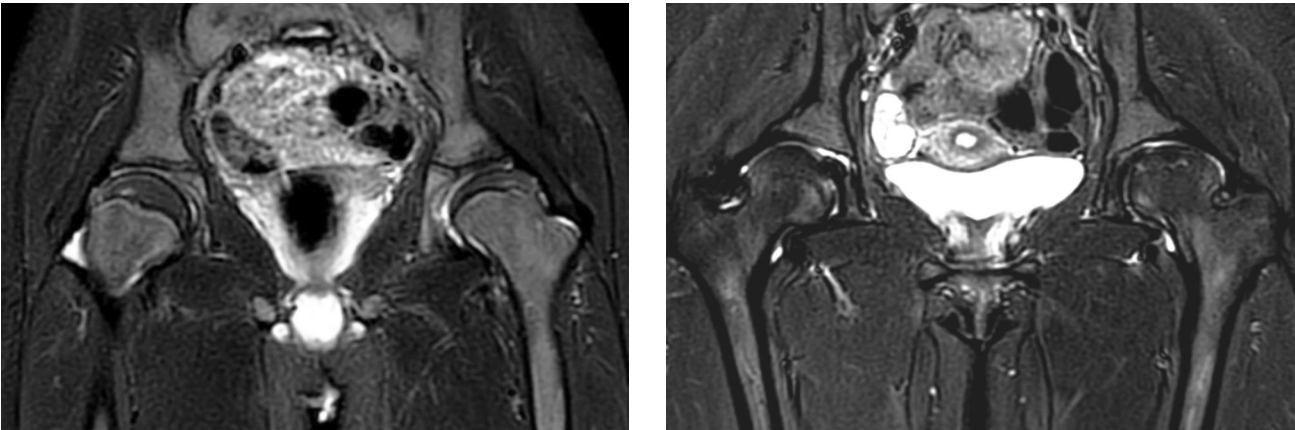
Magnetic resonance imaging in the STIR mode: signs of the inactive stage of osteoarthritis in two children with left-sided Legg–Calvé–Perthes disease after bisphosphonate therapy
